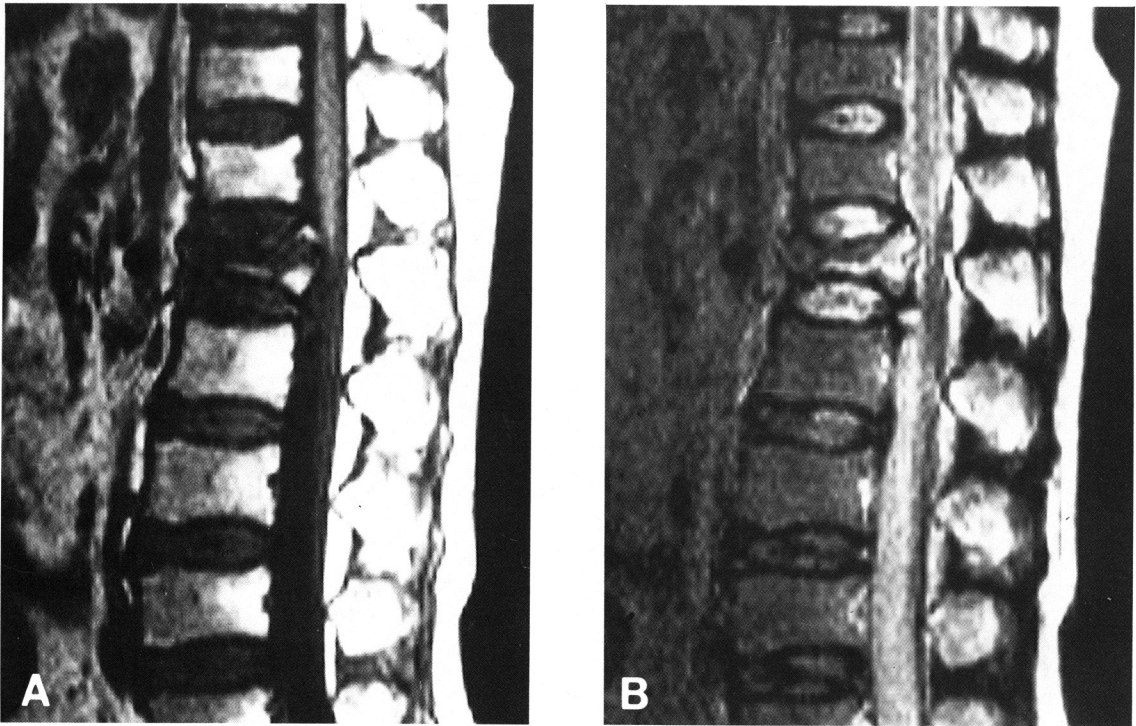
Type Ib compression fracture in a 41-year-old woman with trauma 2 days prior. A, T1-weighted MR image shows patchy hypointensity with preservation of peripheral portion in compressed L1 vertebra. B, T2-weighted image shows hyperintensity in the corresponding area.
